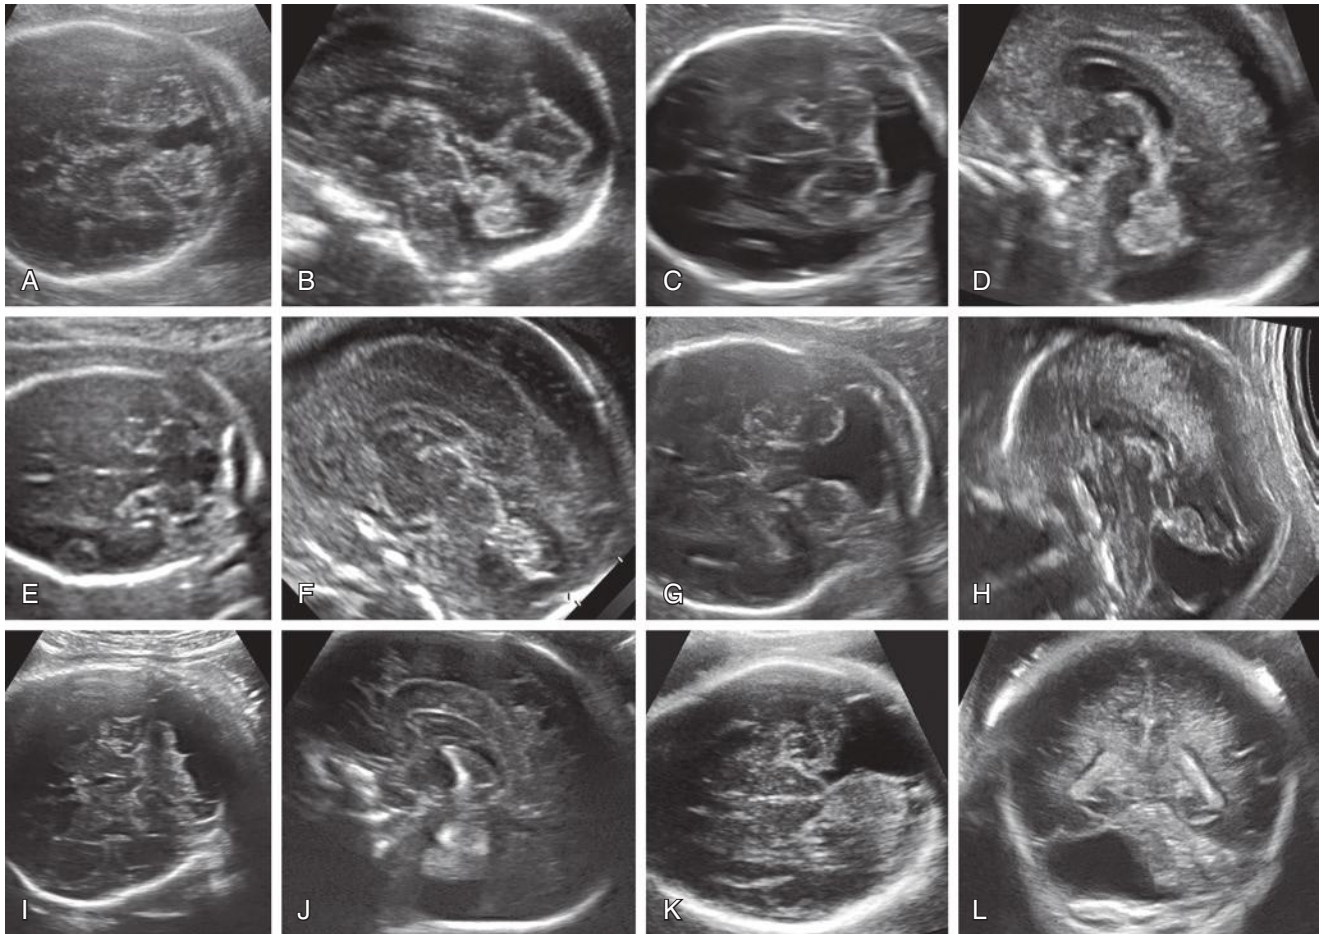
Posterior fossa fluid collections (see Table 9-7). A and B, Blake pouch cyst; C and D, megacisterna magna; E and F, vermian hypoplasia; G and H, Dandy-Walker malformation; I and J, cerebellar hypoplasia; K and L, arachnoid cyst of the posterior fossa. (From Gandolfi Colleoni G, Contro E, Carletti A, et al: Prenatal diagnosis and outcome of fetal posterior fossa fluid collections. *Ultrasound Obstet Gynecol* 39(6):625–631, 2012, used with permission.)
